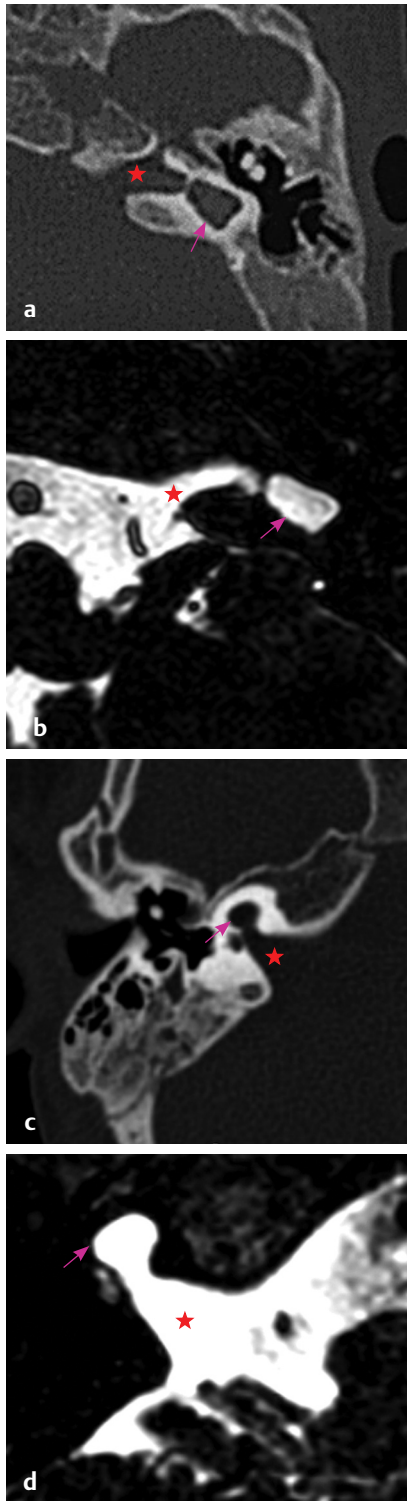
(a, c) HRCT temporal bone, bone window and (b, d) MRI CISS sequence, axial section shows internal acoustic canal (red star) entering the common cavity (pink arrow) in the center.
